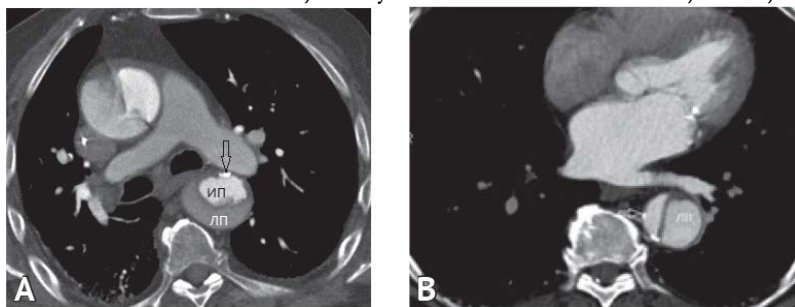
Contrast enhanced computed tomography of patients with aortic dissection. In the descending aorta, calcifications of the non-dissected area (arrows) are determined, which is the wall of the true lumen (ИП). False lumen (ЛП)
